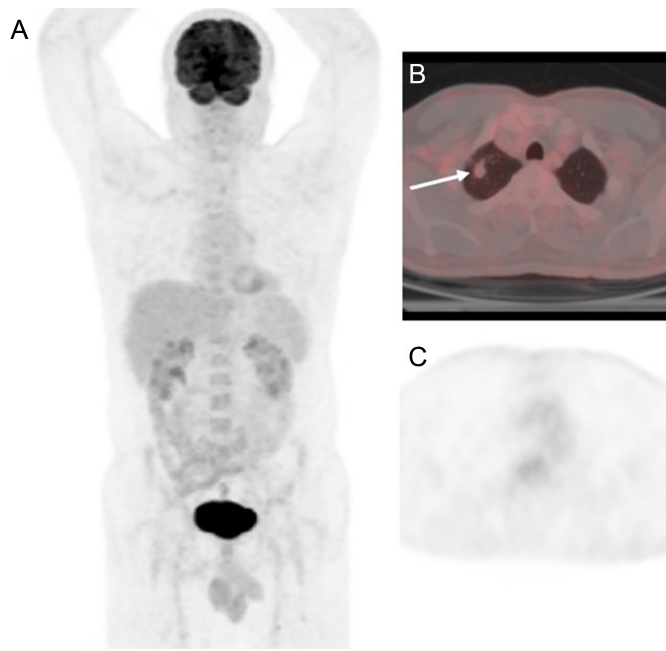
A 61-year-old male patient with pulmonary TB history underwent 18-F FDG PET/CT scan for metabolic characterization of right lung apical segment located nodules. Whole-body maximum intensity projection images are shown (A). Trans-axial fused (B) and PET (C) images showing non-FDG-avid nodules (arrow). CT, computed tomography; 18-F FDG, fluoro-2-deoxy-D-glucose; FDG, fluorodeoxyglucose; PET, positron emission tomography; TB, tuberculosis.
